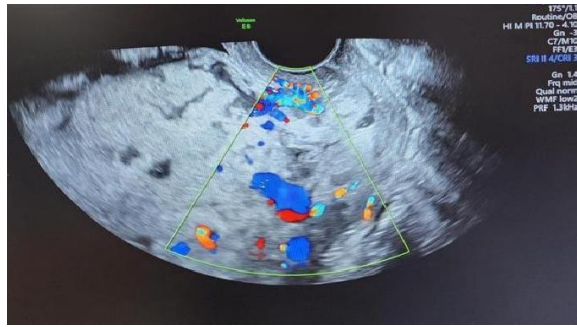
Transvaginal Ultrasound: The placenta implanted in the anteriorcorpus extends to cover the OUI, lacuna (+)
